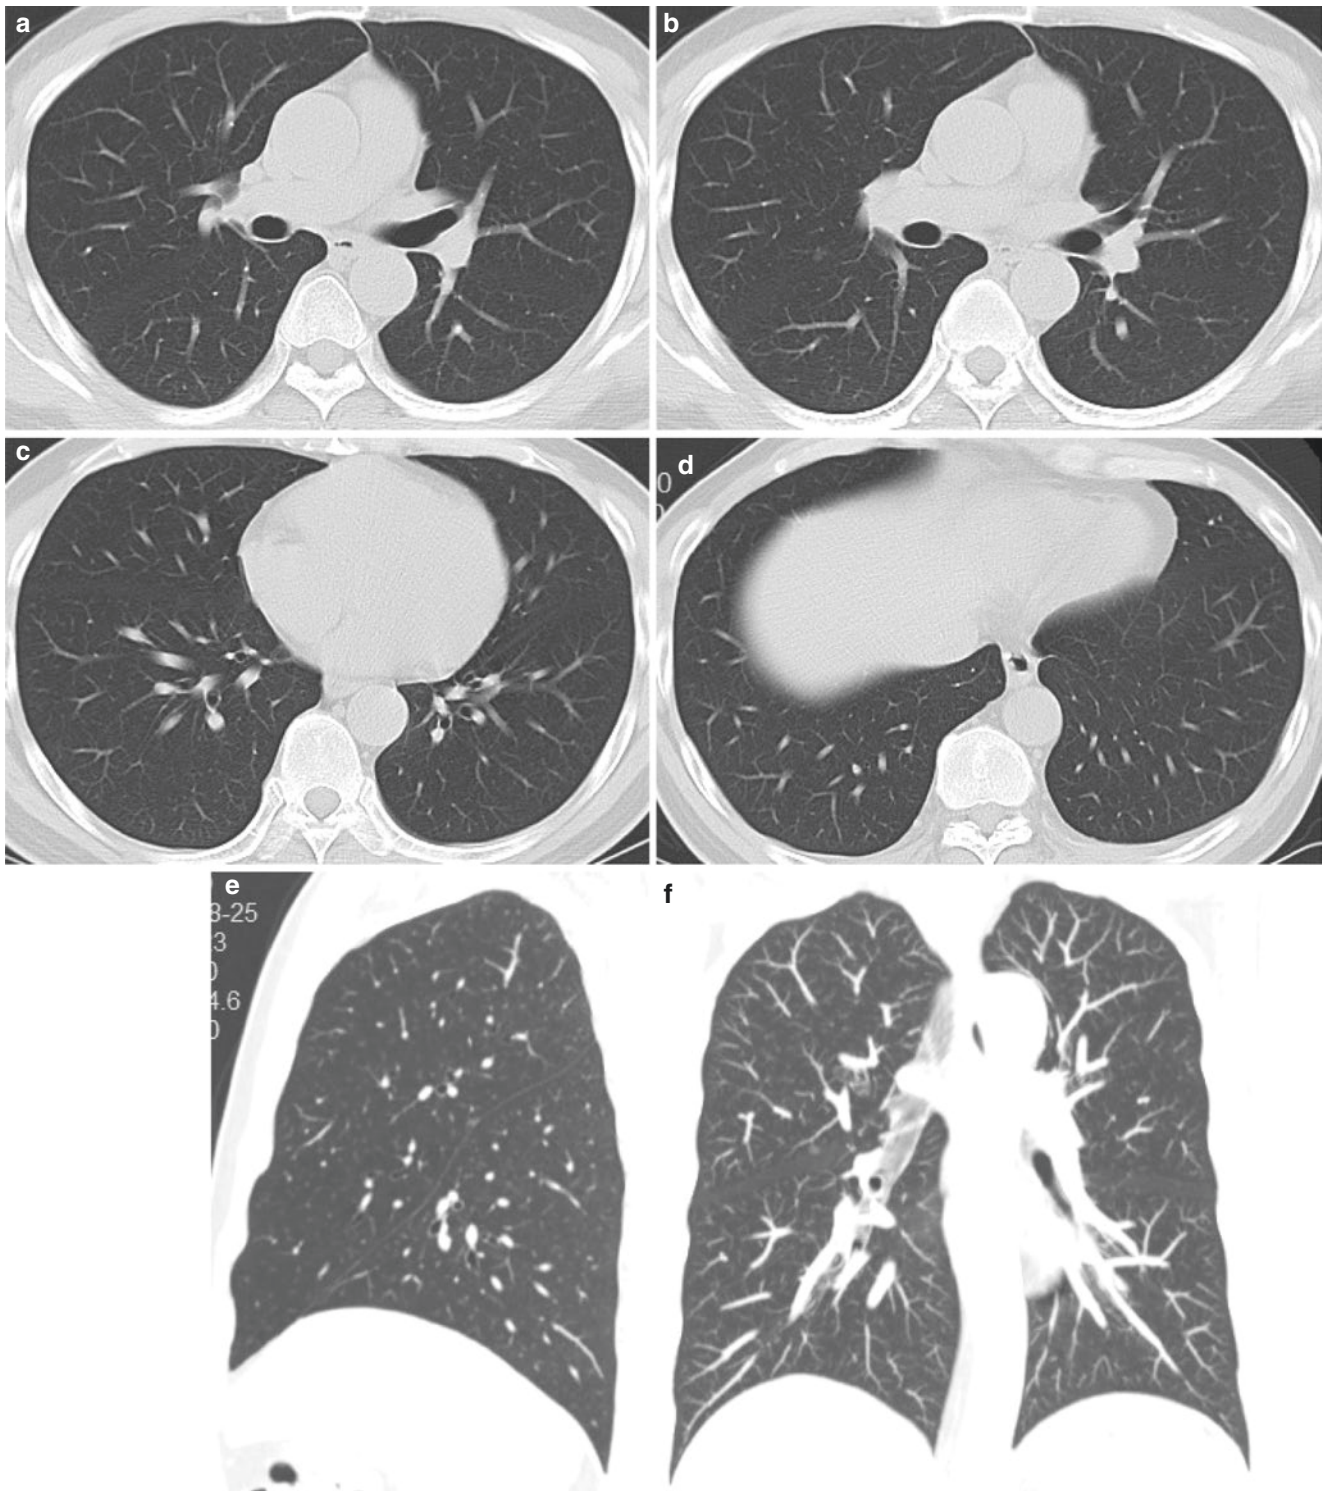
On 194 days after onset of symptoms, chest CT images (a–f) showed linear opacities in the middle lobe of right lung
